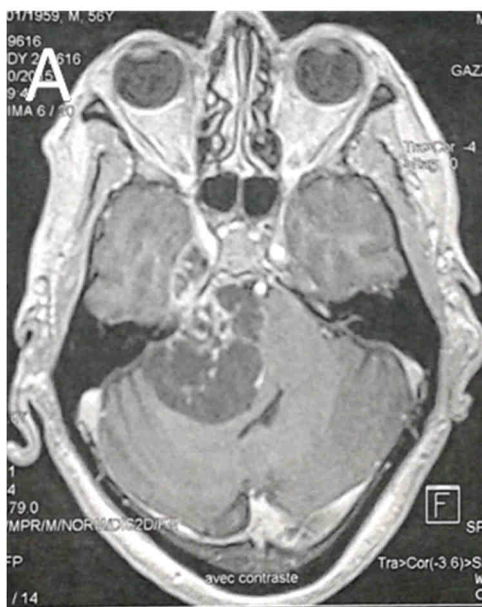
Panel A: Axial B: Coronal: brain magnetic resonance imaging scan showing a cystic mass of the right cerebellar pontine angle
